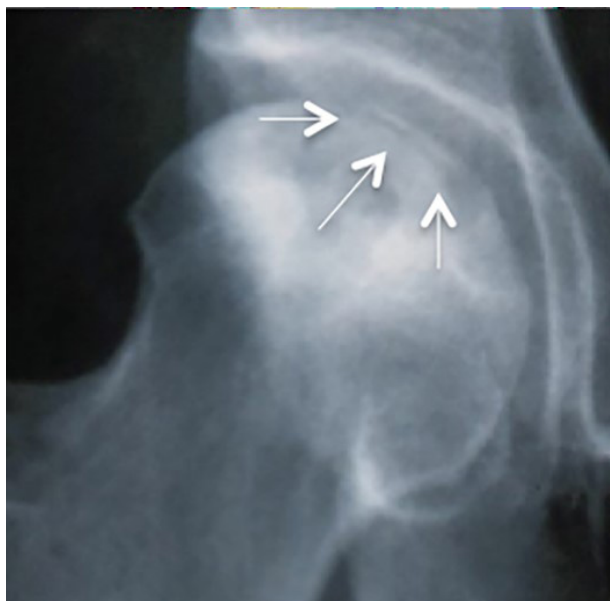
Radiographic image of a femoral head with osteonecrosis depicting the sub-chondral fracture "Crescent sign".
